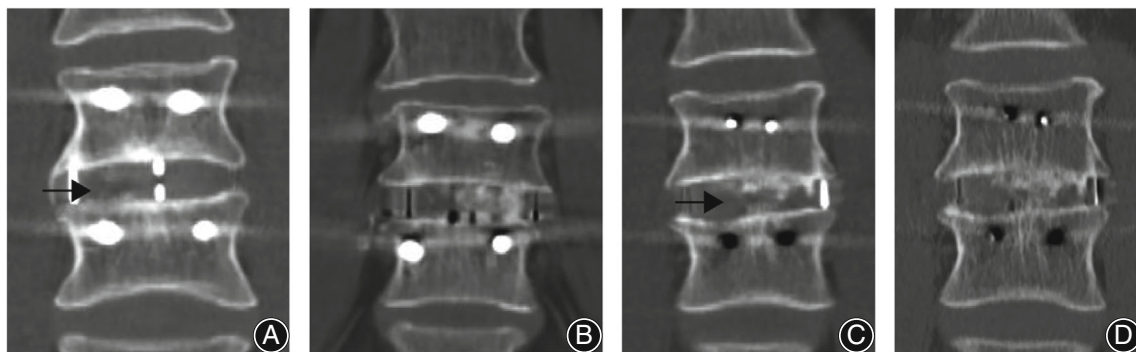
CT evaluation for fusion. At 1-year follow-up, (A) incomplete fusion: absence of continuous bridging bone connecting the adjacent vertebral bodies (arrows). (B) complete fusion: continuous bridging trabecular bone connecting the adjacent vertebral bodies through or around the implants. (C) incomplete fusion at 1-year follow-up in a 59-year-old male who had the operation at L3-4 level proceeded to (D) complete fusion at 2-year follow-up
